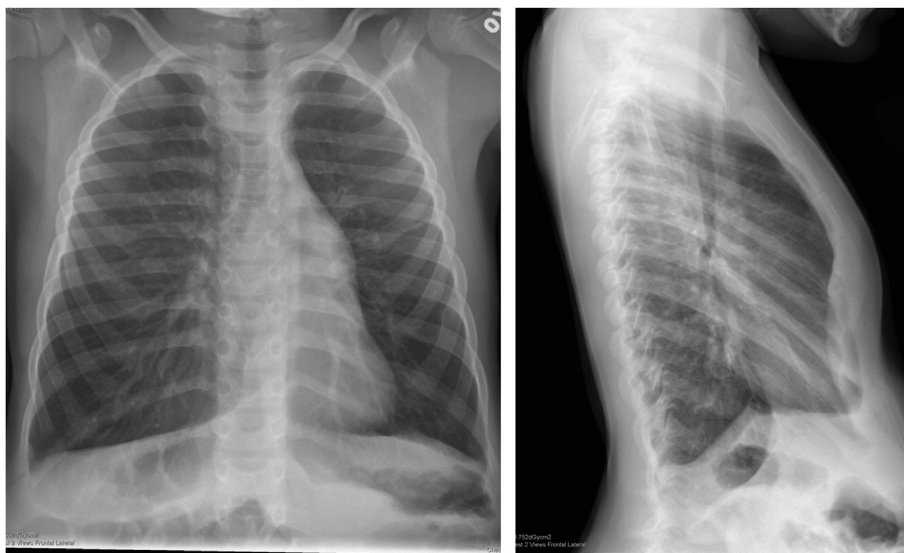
Frontal and lateral chest radiograph one year following bar removal (6 years old) demonstrating a well expanded left lung with minimal residual mediastinal shift and correction of the pectus deformity.
